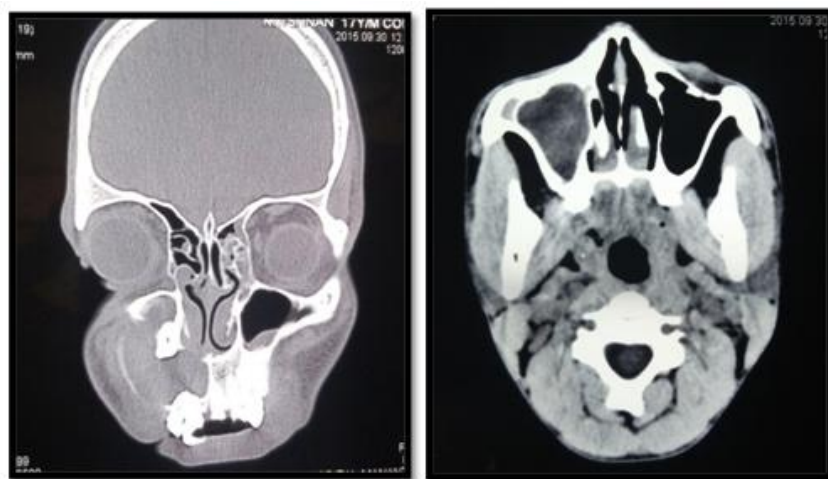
Computed Tomographic views
